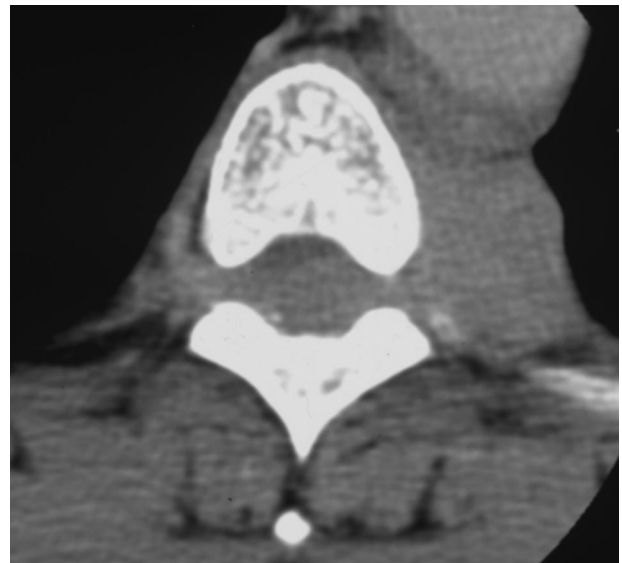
Thoracic spine CT scan shows an epidural mass compressing the spinal cord without bony destruction.
